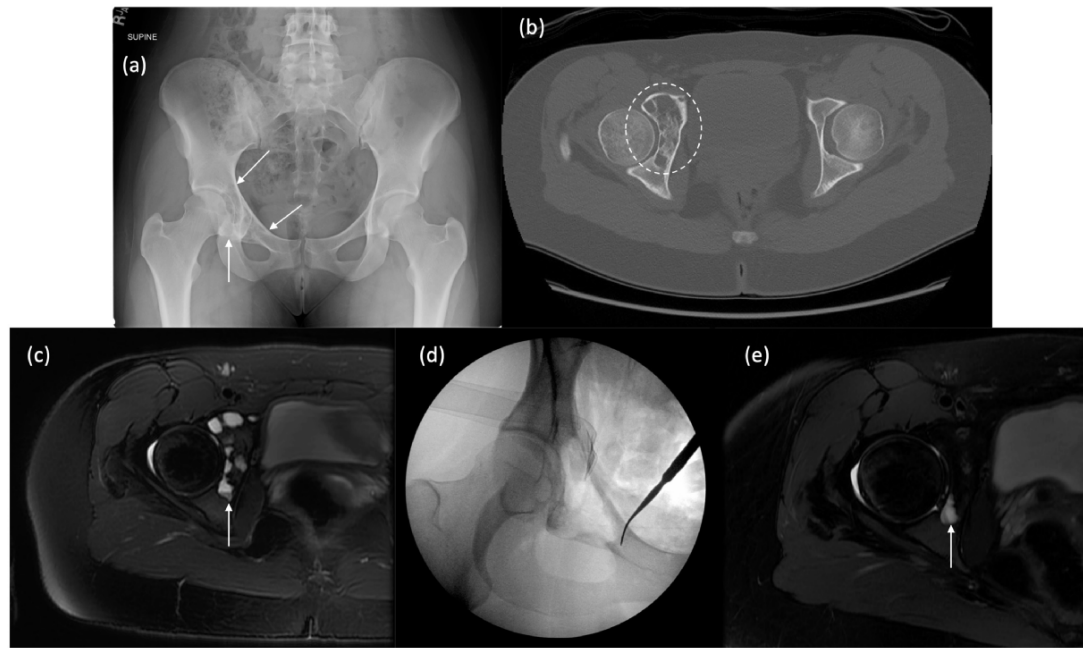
Preoperative and postoperative imaging of the Patient 1's right hip. (a) Preoperative supine AP pelvic radiograph demonstrating an expansile, multilobulated lytic lesion involving the medial acetabulum and extending into the superior pubic ramus (arrows). (b) Preoperative axial CT scan demonstrating a multiseptated lesion involving the medial acetabulum (encircled). (c) Preoperative T2 axial MRI demonstrating a multilobulated cystic lesion with fluid–fluid levels (arrow), favoring appearance of an ABC. (d) Intraoperative fluoroscopic image showing resection of the lesion prior to filling the defect with bone graft. (e) Postoperative T2 axial MRI at the 2-year postoperative interval showing a residual cystic component measuring 1.4 cm in the AP dimension (arrow).
